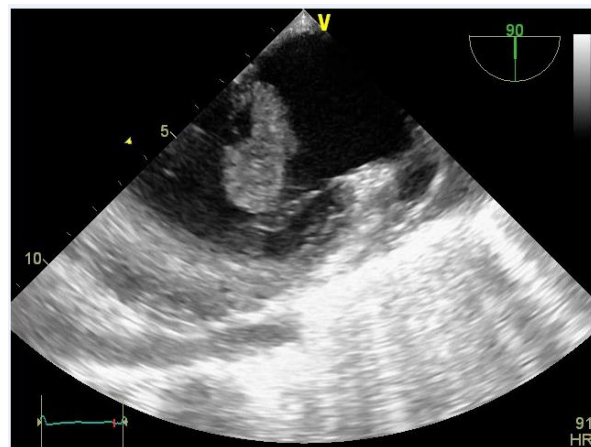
Transesophageal echocardiography revealed a large hyperechoic tumor mass, fluttered across in cavum of left atrium and partially protrude through the opening of the mitral valve.
